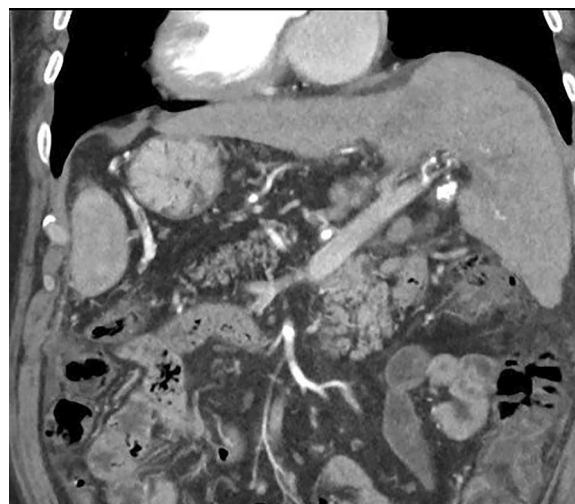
Pre-transplant contrast-enhanced abdominal computed tomography findings showing a complete situs inversus with a mirror-image positioning of abdominal organs
